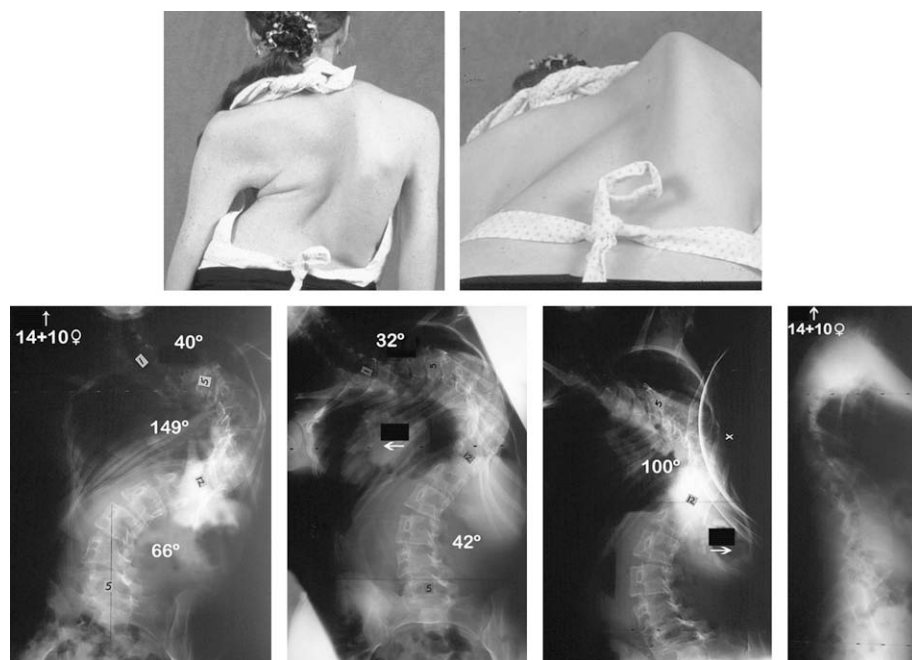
Preoperative clinical photos and preoperative radiographs (anteroposterior, left and right side bending, and lateral).
